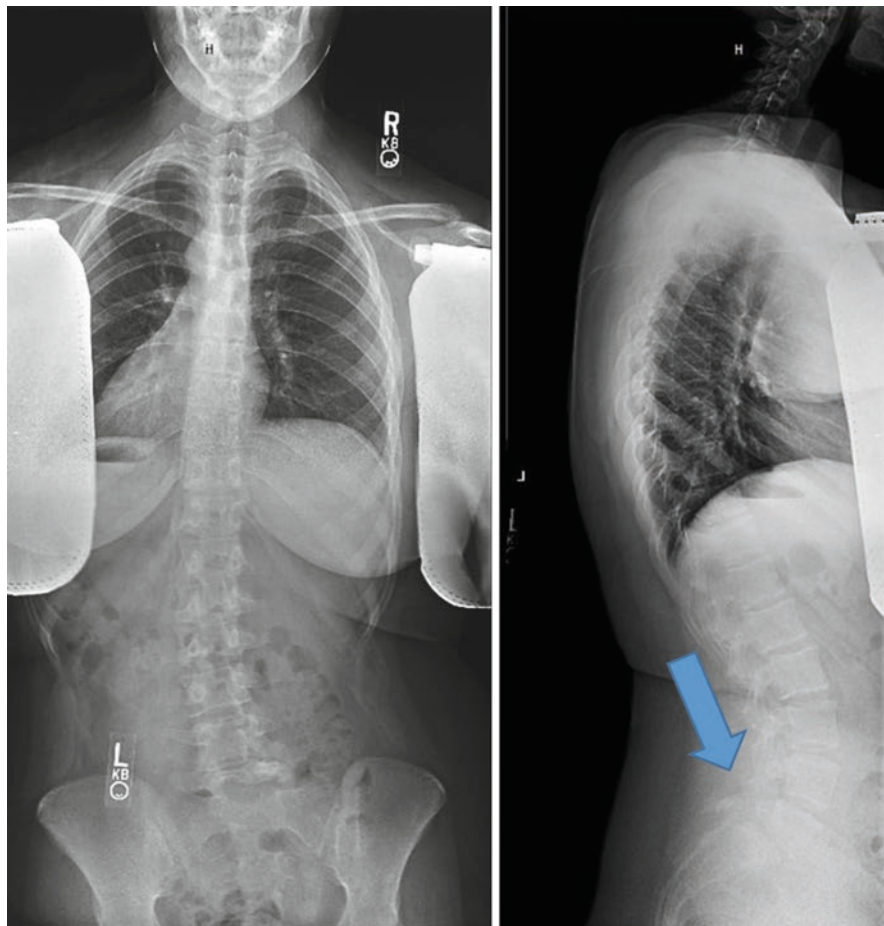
PA and lateral radiograph; bilateral pars interarticularis defects at L5 with mild forward slip of L5 on S1. Note the secondary mild with apex left scoliosis which is frequently seen associated with painful spondylolisthesis. Apex of the secondary scoliosis may be to the left or to the right and is often a long neuromuscular appearing curvature
